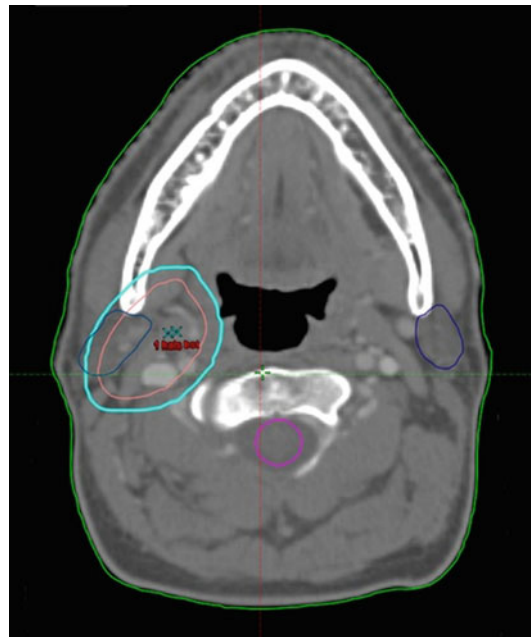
Post-chemotherapy-planning CT scan. CTV: pink. Pre-chemotherapy GTV: red. Pre-chemotherapy PET+ volume: light blue
